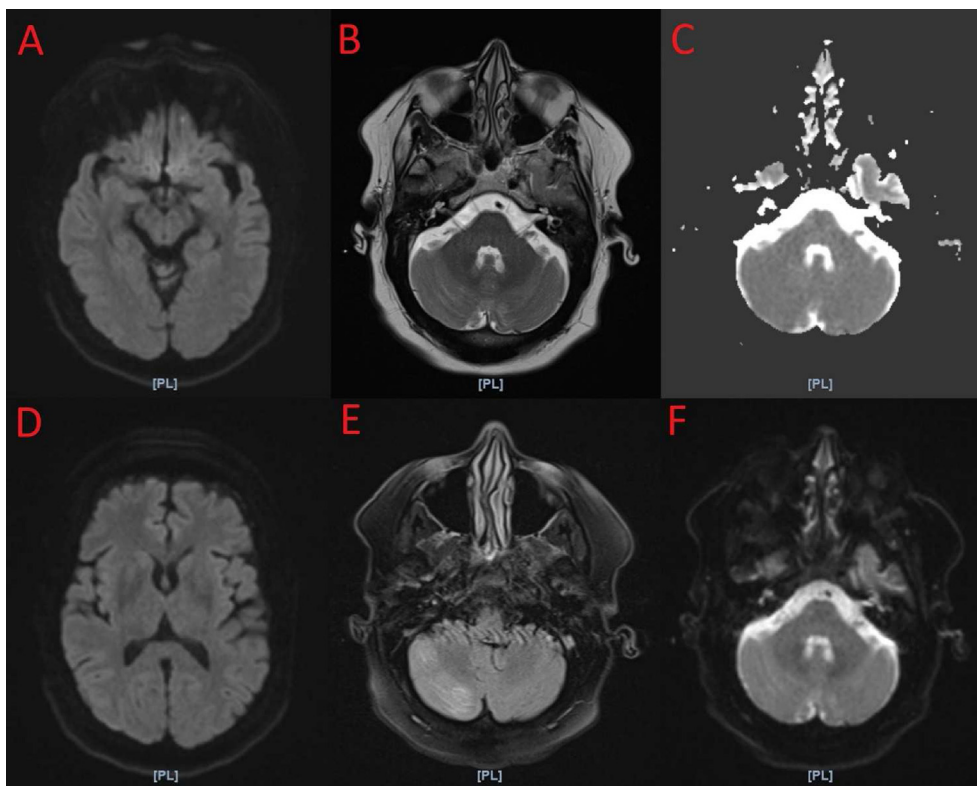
Magnetic resonance imaging (MRI) performed 12 days after the initial presentation. A, D: Diffusion-weighted images with arrows not showing punctate hyperintense lesions in the occipital lobes noted in Fig. 2. B: FLAIR image of the cerebellum showing improved bilateral hyperintensities. C: ADC image of the cerebellum not showing any hypointense abnormalities. E: T2-weighted image showing similar findings to the FLAIR image. F: Diffusion-weighted images of the cerebellum not showing any hyperintense abnormalities.
